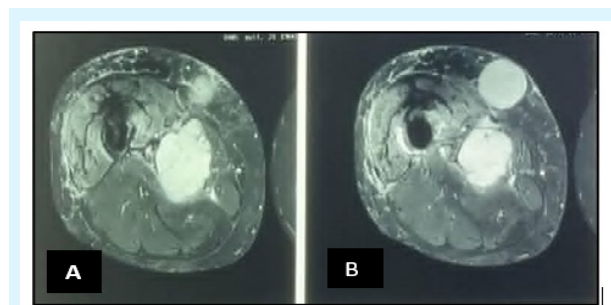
A: MRI showing solid mass in right muscular compartment with hyper-intense T2 signal and heterogeneous enhancement, in contact with superficial femoral artery.
